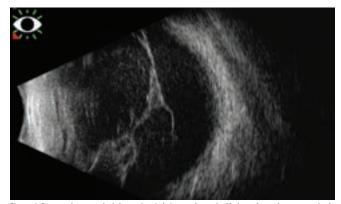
B-scan ultrasound of the patient's left eye showed a V-shaped membrane attached
